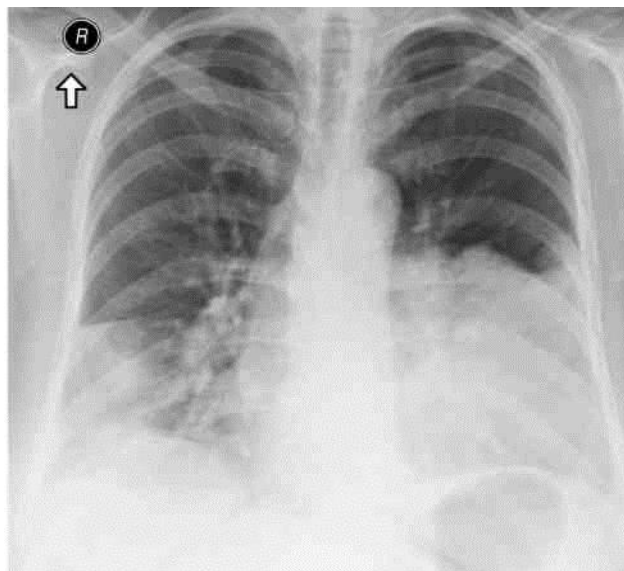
Posteroanterior chest X-ray (3/02/2013). Lower lobe consolidation and a right pleural effusion, reaching anterior part of rib IX. Middle and lower field opacities, consolidation and a left pleural effusion.
